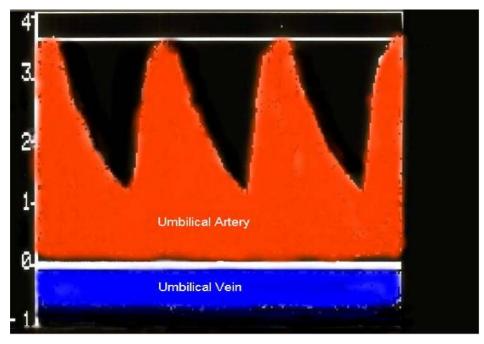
Normal waveform of the umbilical cord obtained with CW Doppler. Note the simultaneous pulsatile umbilical artery (red) and non-pulsatile umbilical vein (blue).
